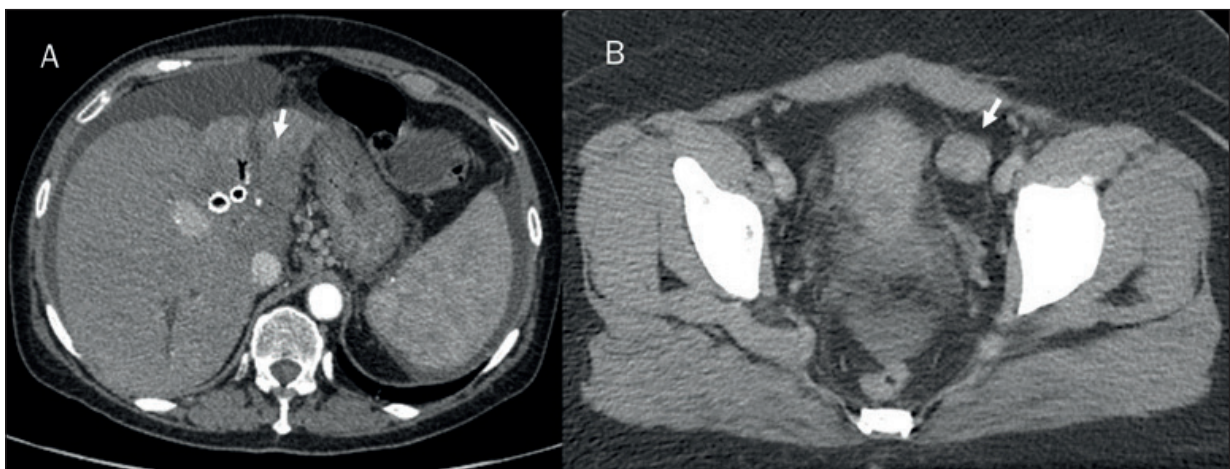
Patient with Periductal Cholangiocarcinoma assessed on contrast CT study. In A, the arrow shows the primary lesion and in B the ovarian involvement.
